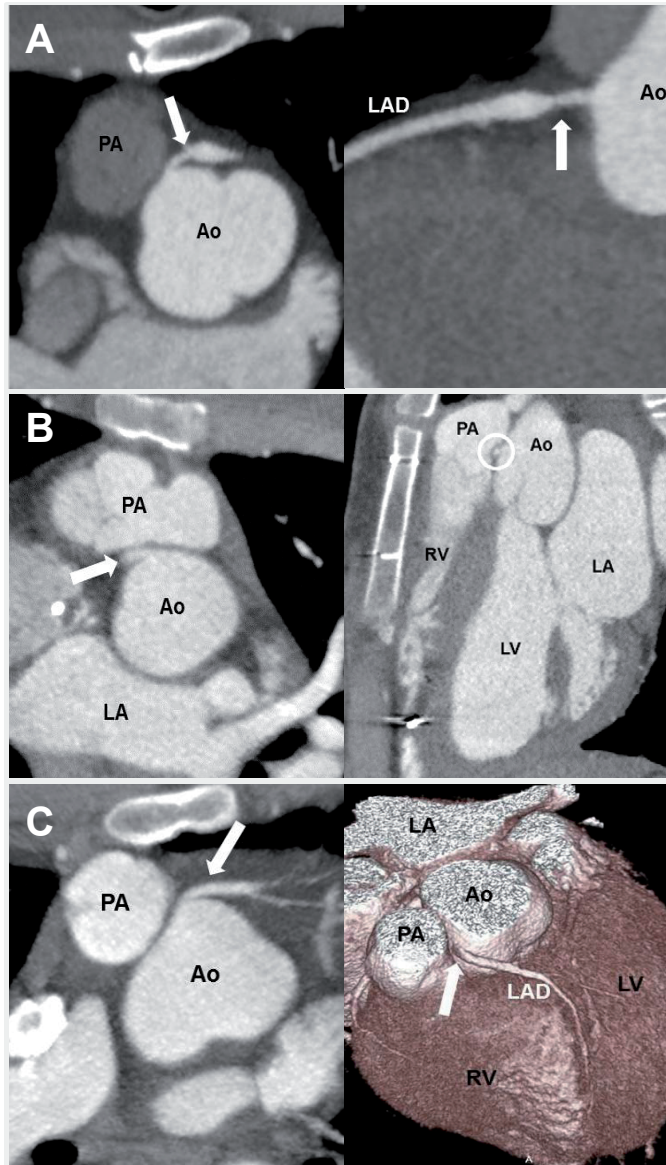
Case examples of patients with abnormal coronary findings on CTA.
